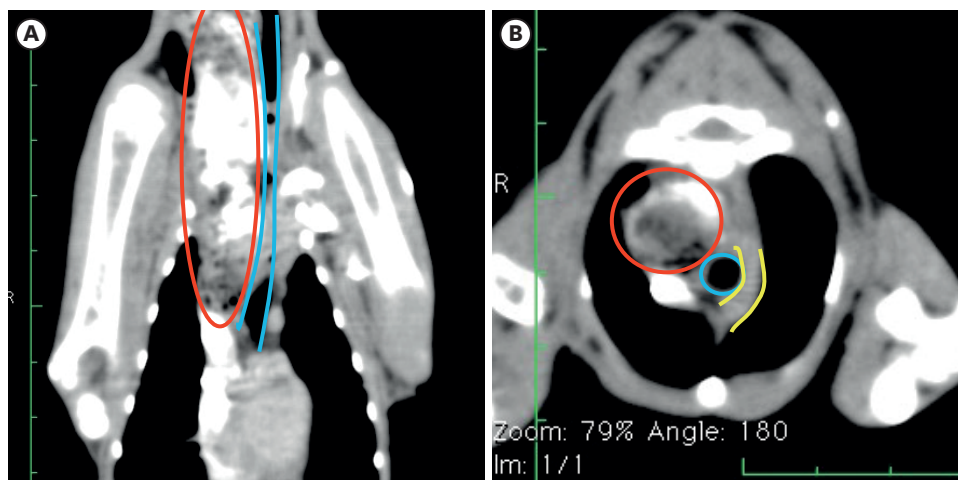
Cardiac computed tomography. Dilated esophagus (red line) displaced the trachea (blue line) to the left side (A) and left aortic arch (yellow line) situated on the left side of the trachea (blue line) and the esophagus (red line) (B).
